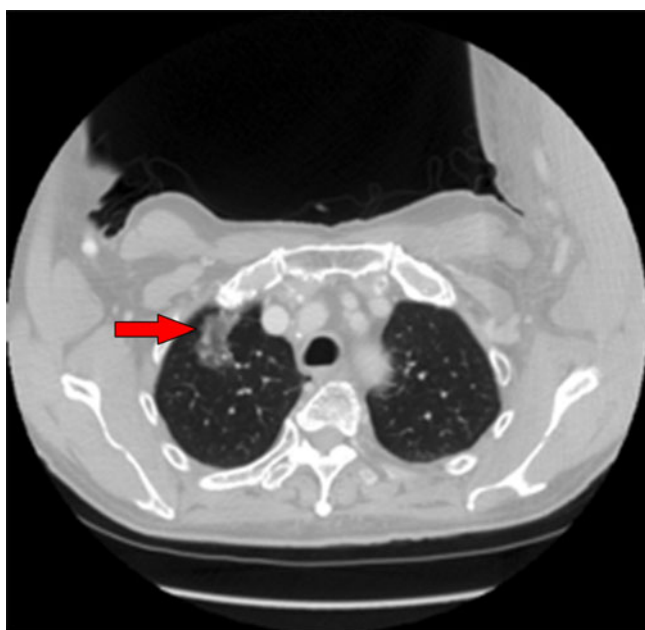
Chest CT image.
